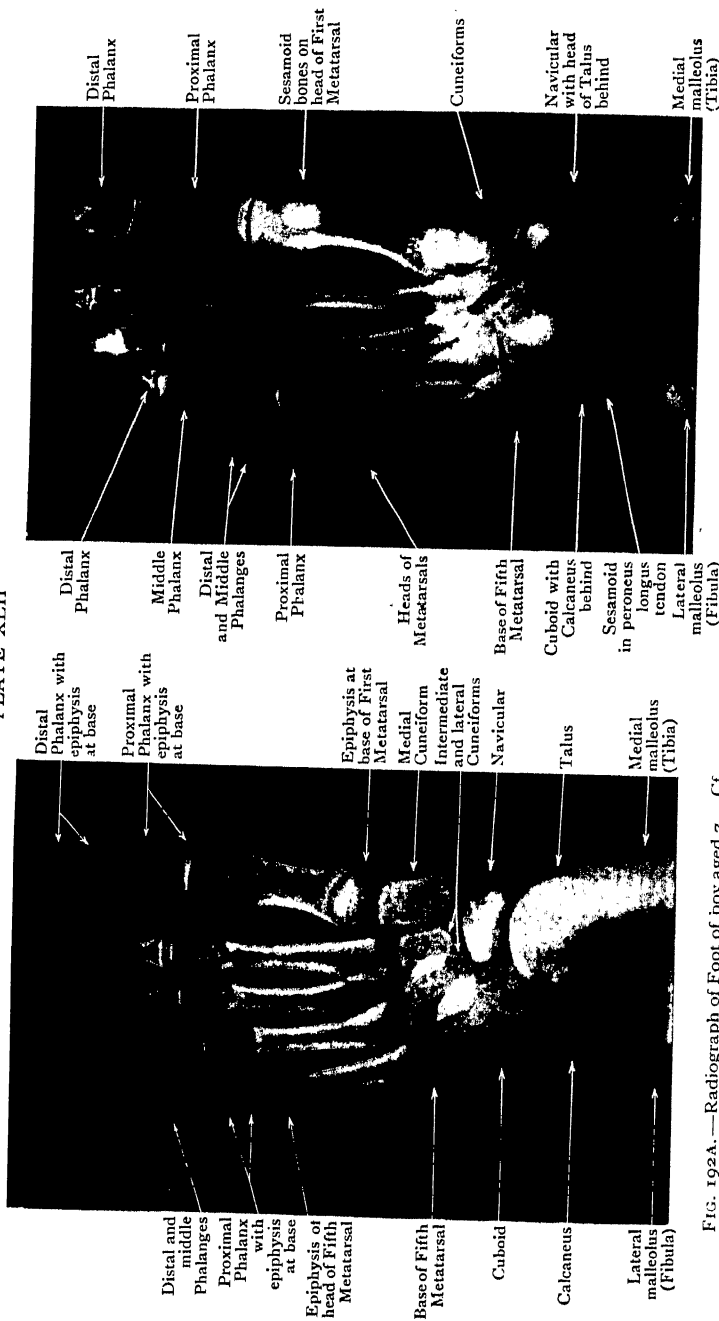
Radiograph of Foot of boy aged 7. Cf. Fig. 94A, p. 182, noting that the Tarsus is more advanced in ossification than the Carpus, but that the Phalanges of the toes are less advanced than those of the fingers.
